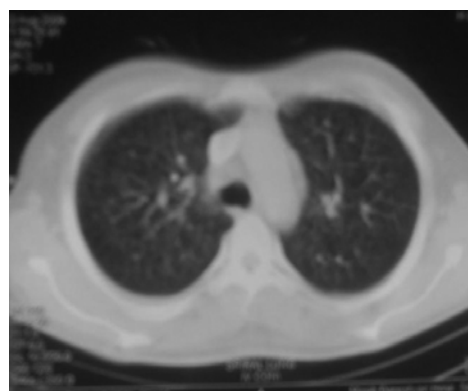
Spiral CT-scan of the patient.
